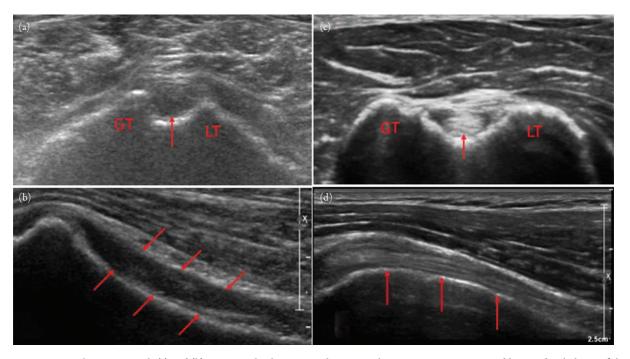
Biceps tendon tear. Panels (a) and (b), respectively, show grayscale sonographic images in transverse and longitudinal planes of the proximal anterior shoulder in the region of the intertubercular groove. The biceps tendon is completely torn and distally retracted and is not visible in the intertubercular groove (arrows). Panels (c) and (d), respectively, show a normal proximal long head of the biceps tendon in normal position in the intertubercular groove for comparison.
